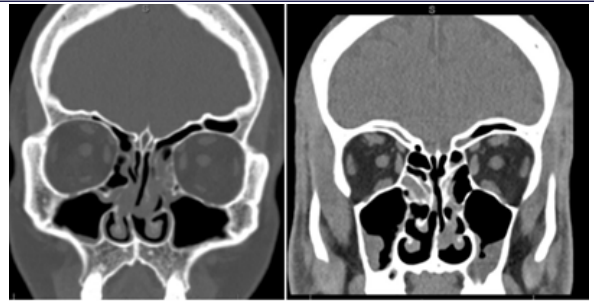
Figure (c) 41 years old male CT coronal view showing patient with sinonasal polyposis with nasal septal deviation to left side. Figure (d) 61 years old male CT coronal view showing patient with chronic sinusitis with features of invasive fungal sinusitis in left frontal and posterior ethmoidal air cells.
